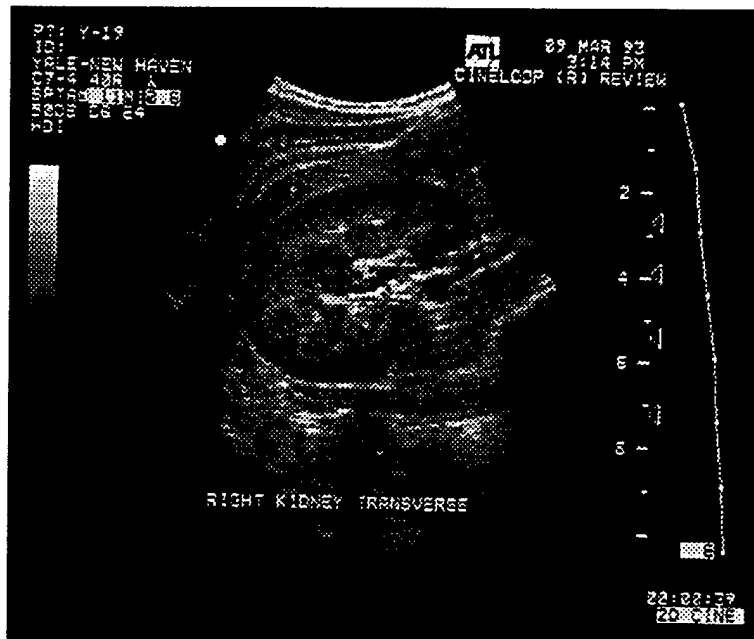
Typical Ultrasound Image of Kidney
